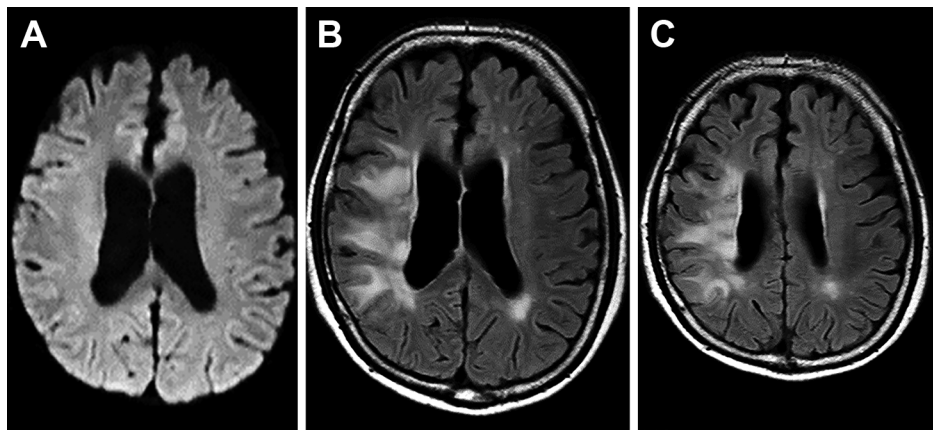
Axial view of brain magnetic resonance imaging 1 week after admission.
